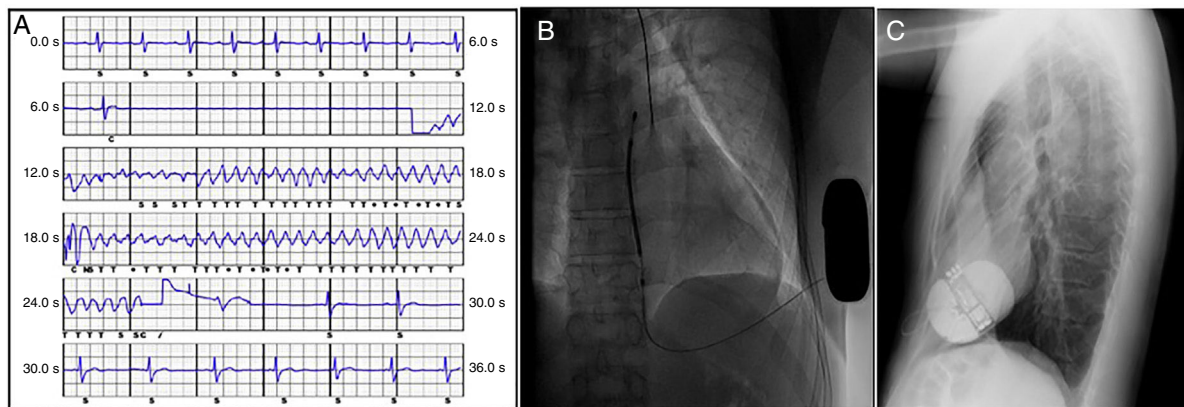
Ventricular fibrillation induction report (A), posteroanterior chest radiography (B), and lateral chest radiography (C) following placement of a subcutaneous implantable cardioverter-defibrillator.
